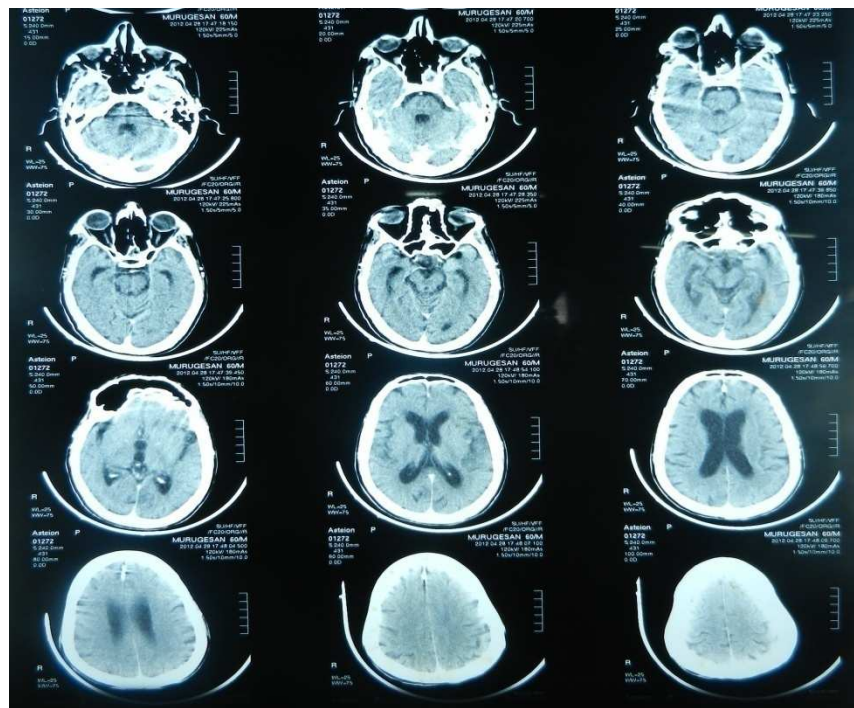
MRI SCAN OF THE PATIENT SHOWING PRESENCE OF
